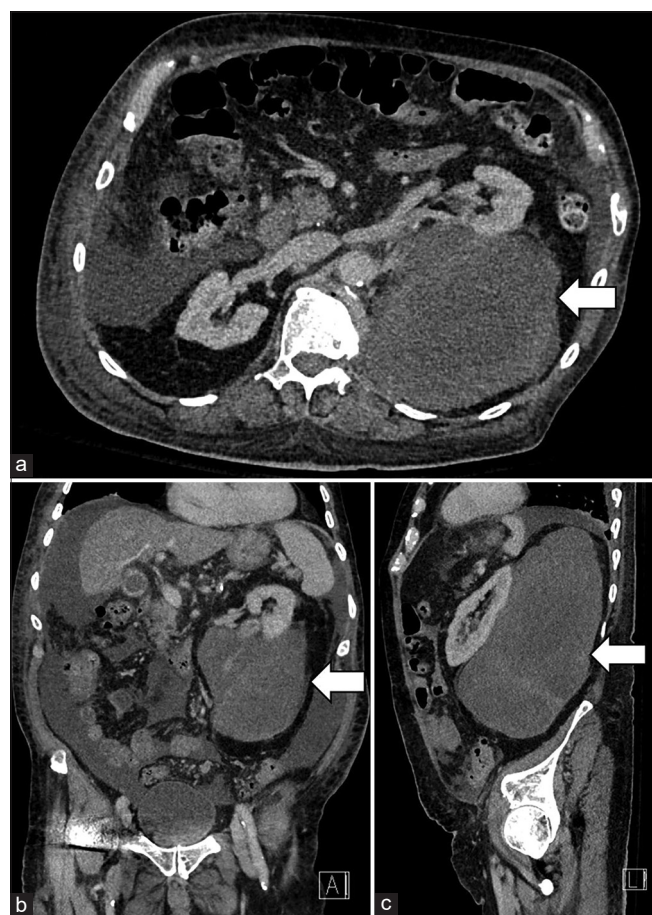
An 86-year-old male with cystic retroperitoneal dedifferentiated liposarcoma who presented with unexplained weight loss and frequent falls. Axial (a), Coronal (b), and Sagittal (c) contrast enhanced computed tomography (CT) images of the abdomen and pelvis in the portal phase demonstrate a large heterogenous complex cystic lesion in the left retroperitoneum (arrows). Differential considerations on CT included a complex hematoma, abscess, or a cystic tumor.
